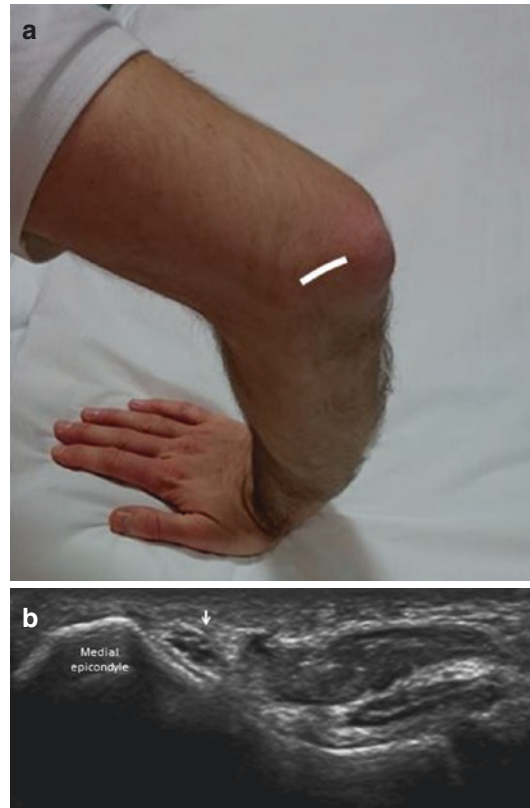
Ulnar nerve. Transducer placement (a). Ulnar nerve (b) (arrow) in the elbow courses through the cubital tunnel, a retroepicondylar osseous groove at the postero-medial aspect of the elbow. It is evaluated using ultrasound on short-axis planes
